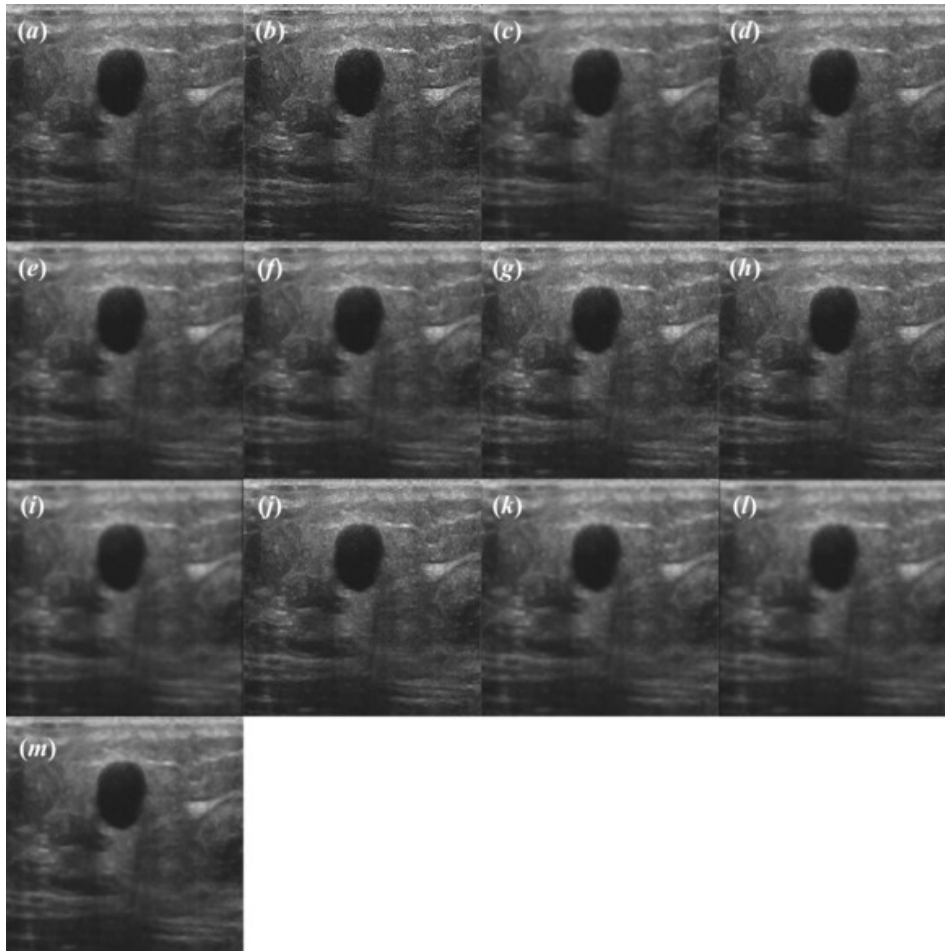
(a) Sample original ultrasound image of benign tumor and (b)-(m) corresponding images despeckled by (b) Shock filter, (c) Median filter, (d) HyMedian filter, (e) Homog filter, (f) Homo filter, (g) Geometric filter, (h) SRAD filter, (i) AD filter, (j) DPAD filter, (k) CA filter, (l) LS filter and (m) Ecasort filter.
